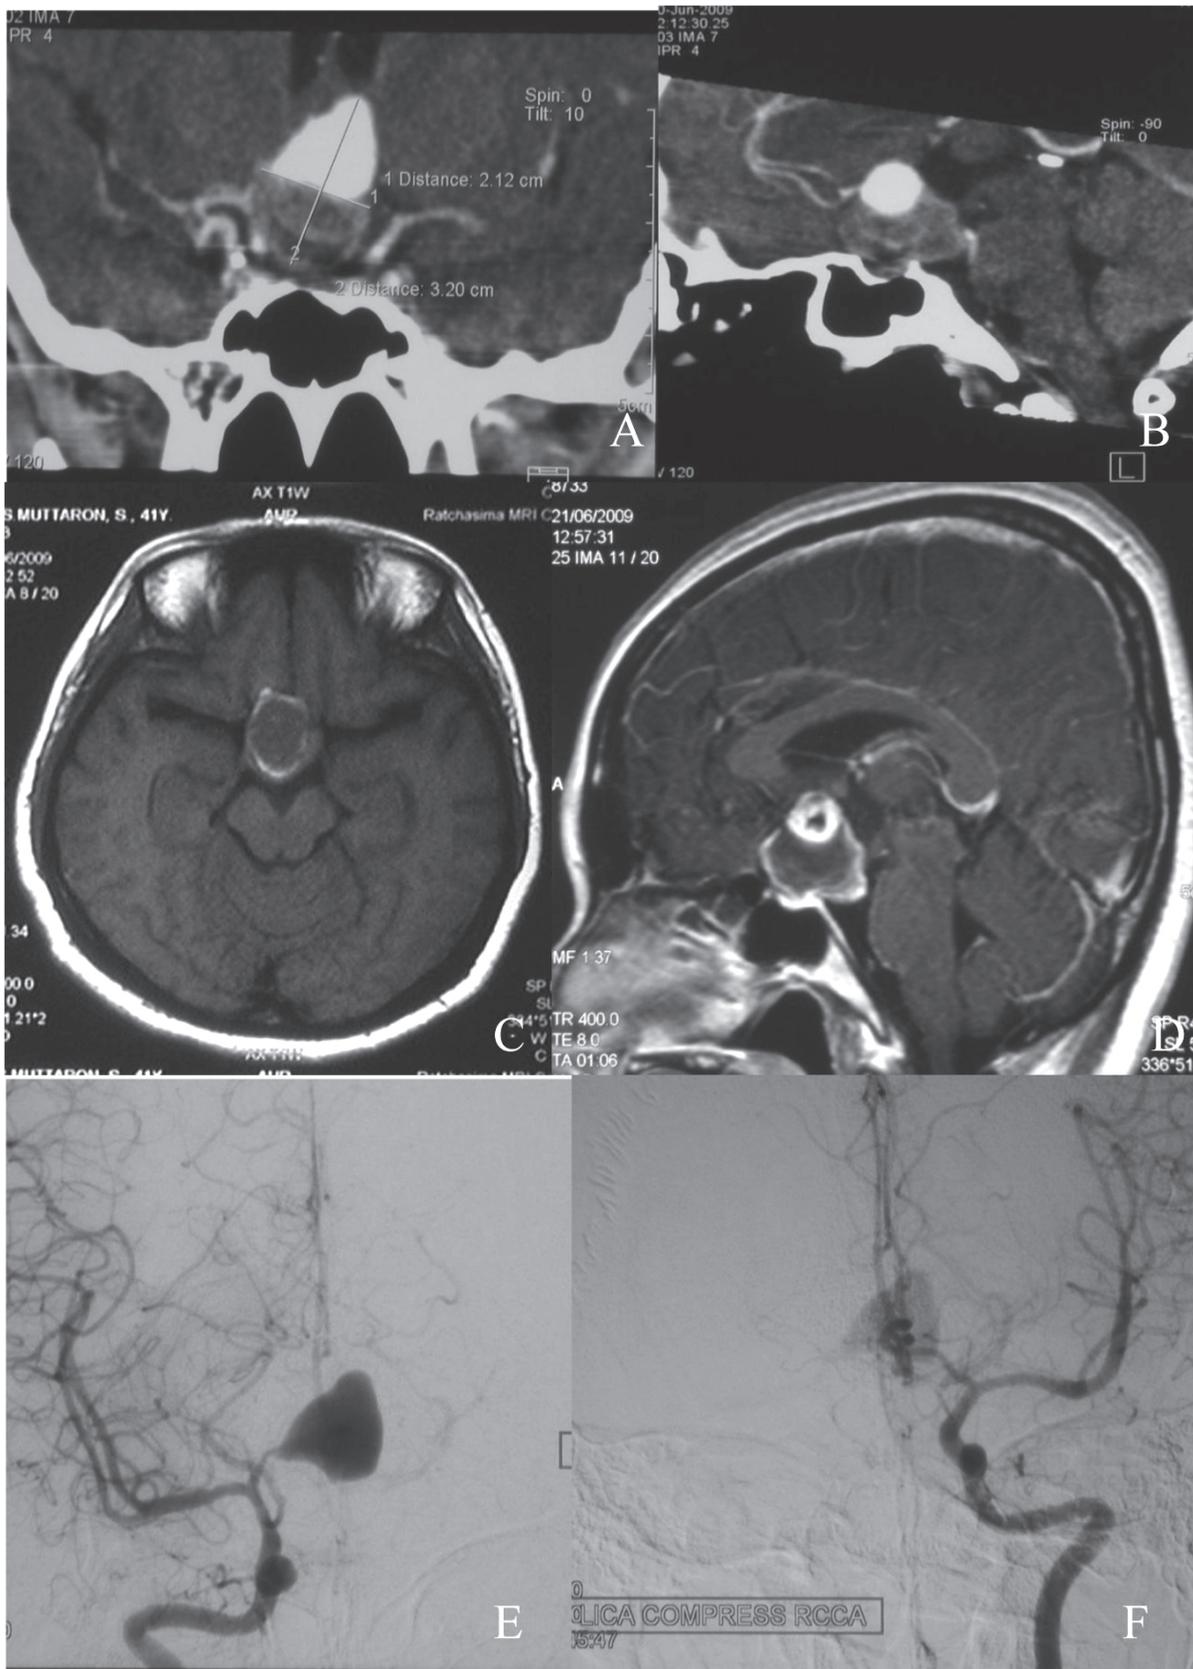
A 41-year-old female (case NO.8) presented with headache and visual field defect. A CT angiography (A,B) and MRI (C,D) revealed a partially thrombosed giant A1-AcoA aneurysm. DSA revealed a giant A1-AcoA aneurysm fed from Rt.A1 (E). Good cross-flow from Lt.A1 to Rt.ACA with patent AcoA was demonstrated on Lt.ICA injection with compress Rt. carotid artery (F).
